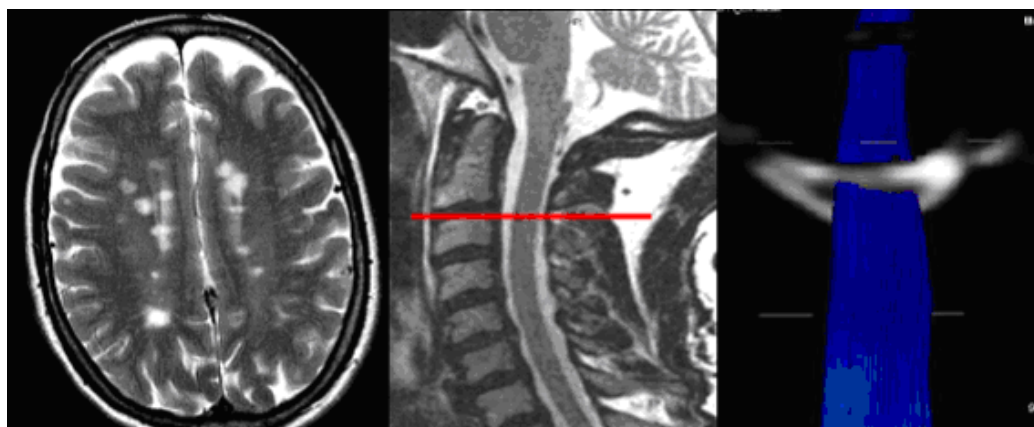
Left—Axial T2-weighted MR image of patient with relapsing-remitting multiple sclerosis. Center—Sagittal image demonstrates absence of cervical spinal cord signal abnormality. Right—Axial b=0 diffusion-weighted image at the C2-C3 level (red line, center image) with superimposed three-dimensional diffusion fiber tractography.
